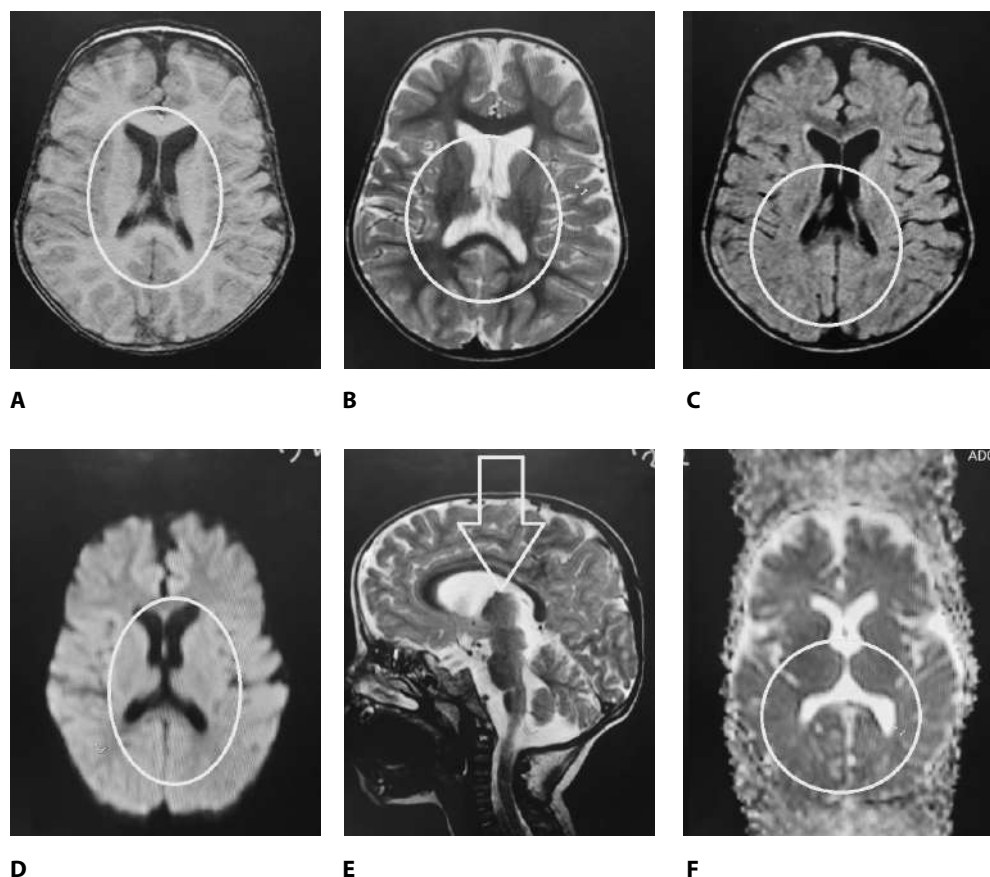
4-years-old boy (Brain atrophy): A. T1WI axial. B. T2WI axial. C. T2-FLAIR: show mild dilated lateral ventricles with prominent frontal and temporal sulci. D. DW: free diffusion. E. T2 sagittal: mild dilated CSF spaces. F. ADC map: normal diffusion
